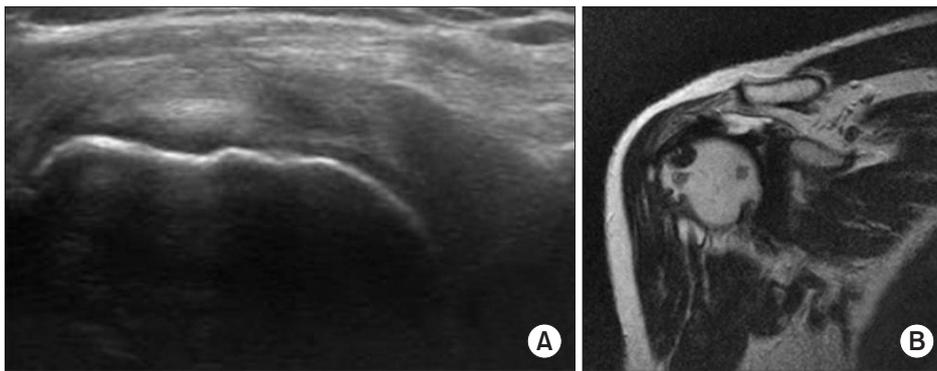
Image evaluations of the ultrasound and magnetic resonance imaging (MRI). (A) No definite tear was seen on the ultrasound. (B) T2 coronal MRI showed the type 2 retear (rupture in the musculotendinous junction remaining the footprint).
